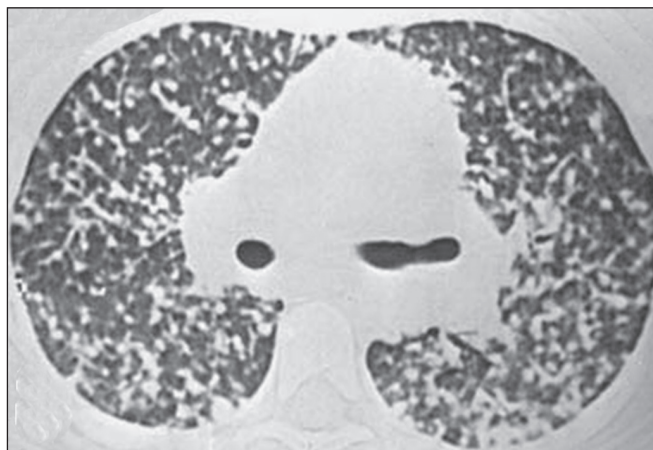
CT of a 6-year-old with positive serology, showing small nodules disseminated throughout both lungs. Note also the bilateral hilar lymph node enlargement.
